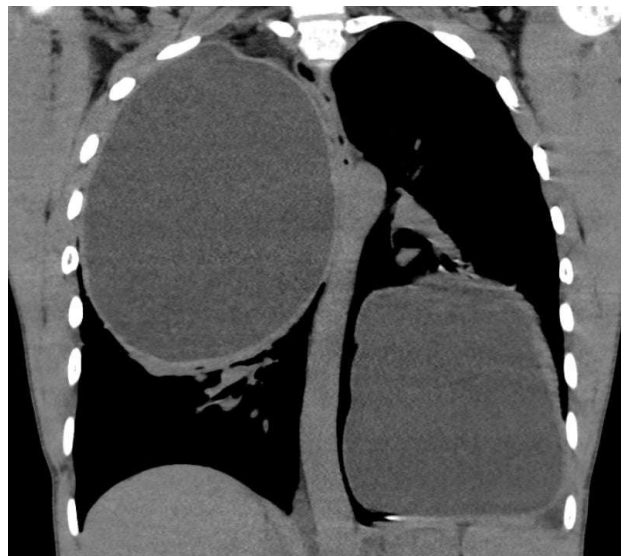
computed tomography scan of the chest (coronal view) showing two giant hydatid cysts on both sides of the chest.
